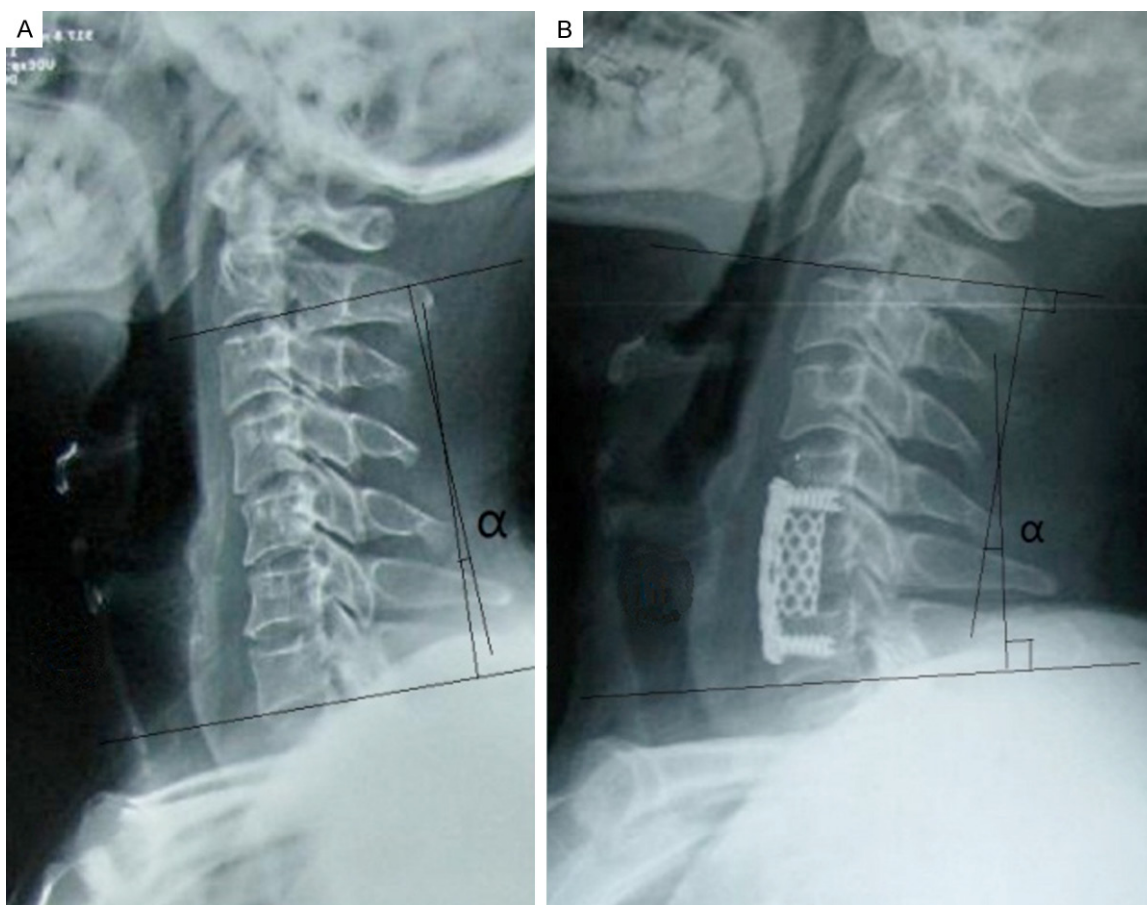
Measurement of cervical Cobb angle: In the neutral position, a cervical lateral radiograph was obtained, and 2 straight lines parallel to the edge of the C3 and C7 vertebral bodies were drawn. The angle between 2 straight lines was measured as Cobb angle. Preoperative (A) and postoperative (B) Cobb angles.
